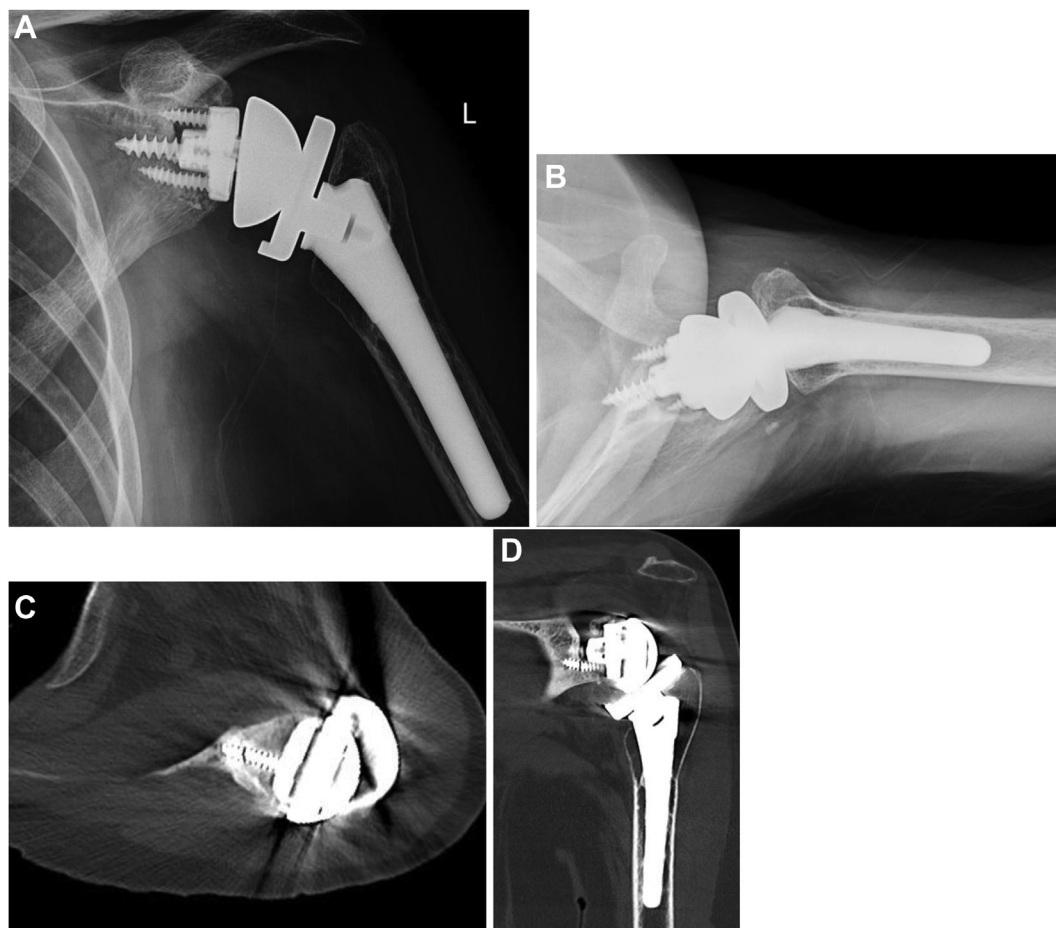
Imaging taken 10 months after the revision to rTSA. (A and B) are radiographs of the left shoulder in the AP and lateral planes demonstrate signs concerning for glenoid component loosening. (C and D) are CT imaging in the axial and coronal planes further indicating glenoid component loosening and hardware failure of a screw in the inferior glenoid. rTSA, reverse total shoulder arthroplasty; CT, computed tomography.
